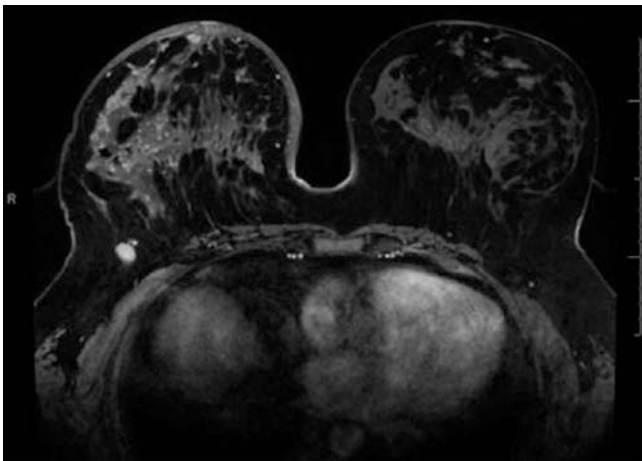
Breast MRI of a patient with right inflammatory breast cancer. Note the large mass-like enhancement and skin thickening on right compared to left. This patient had no palpable breast mass. (Arrow denotes an abnormal axillary lymph node)
